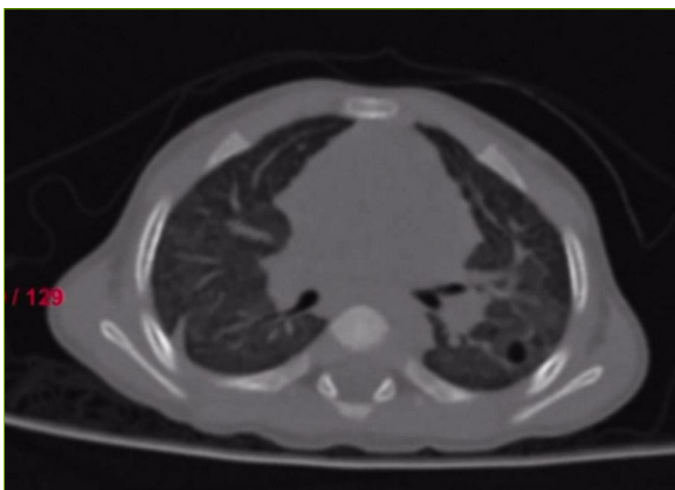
CT Thorax after 6 months of treatment
